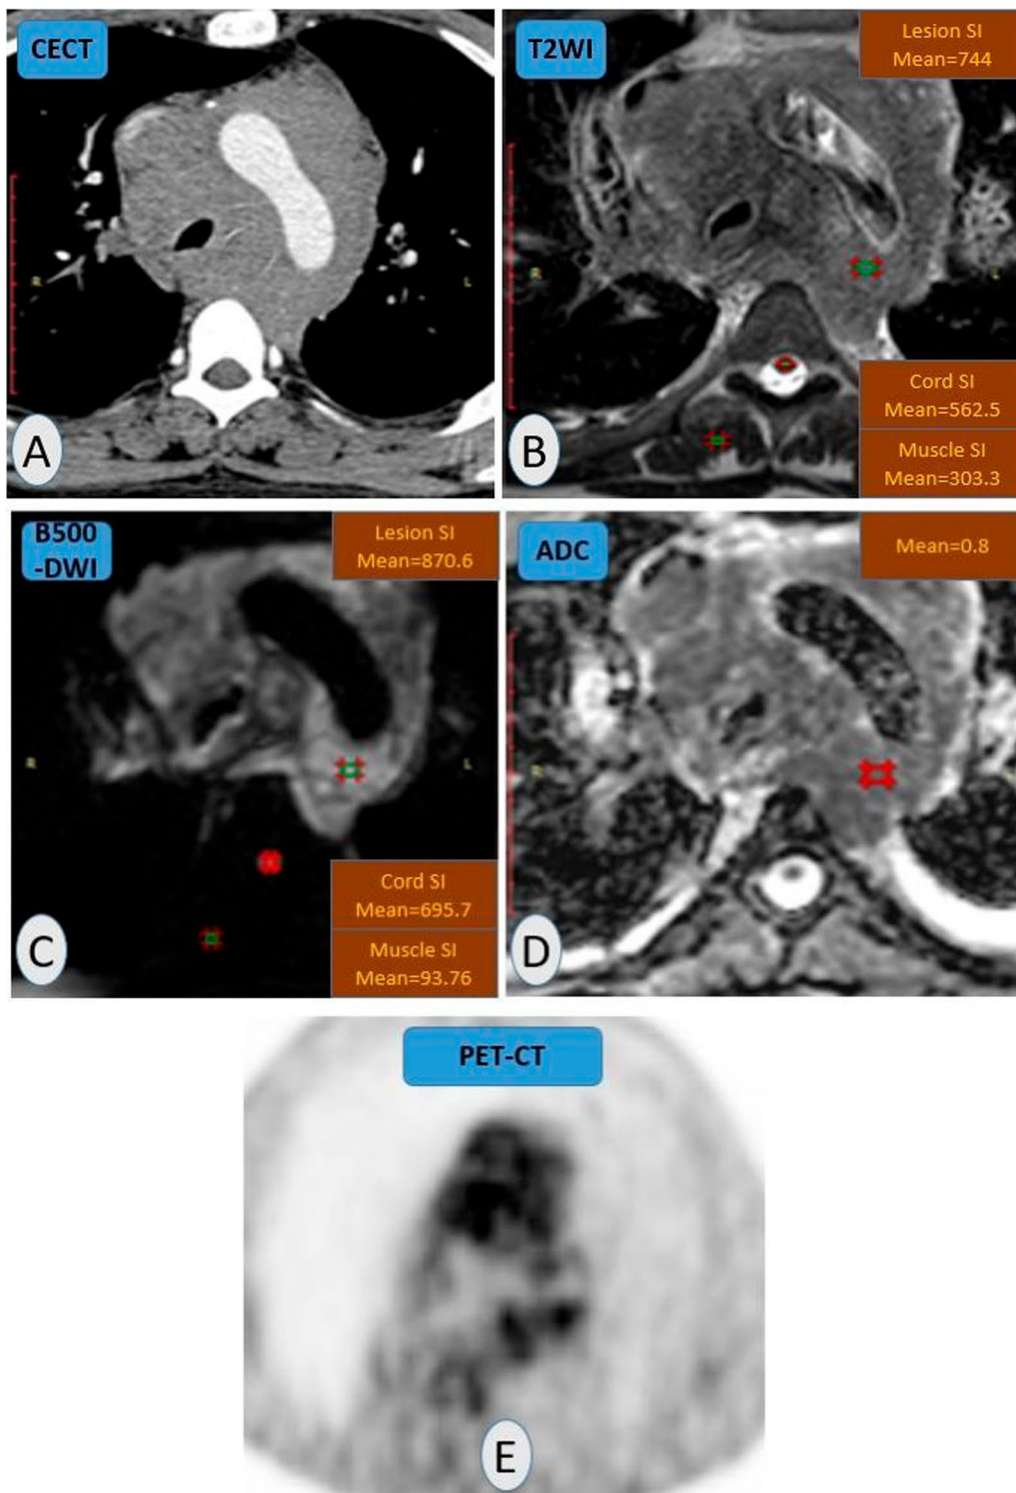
A 23 years-old-male patient with dyspnea, palpitation, cough, and weight loss. A Contrast-enhanced chest CT showed a large anterior and posterior mediastinal hypo-enhancing nodal mass totally encasing the aortic arch and trachea. B T2WI-MRI showed iso to mild hyper-intense signal (compared to muscle signal) with lesion-to-cord ratio = signal 1.3 and lesion-to-muscle signal ratio = 2.4 (N.B: Signal intensity is even measured at the brightest part of the lesion). C b500-DWI showed only a focal bright signal at left posterior nodal tissue with lesion-to-cord signal ratio = 1.3 and relative contrast ratio = 5.3. D Mean ADC value = $0.8 \times 10^{-3} \text{ mm}^2/\text{s}$ (positive restriction). E PET-CT examination with high FDG uptake (hot spot) ... Pathologic proven non-Hodgkin lymphoma
